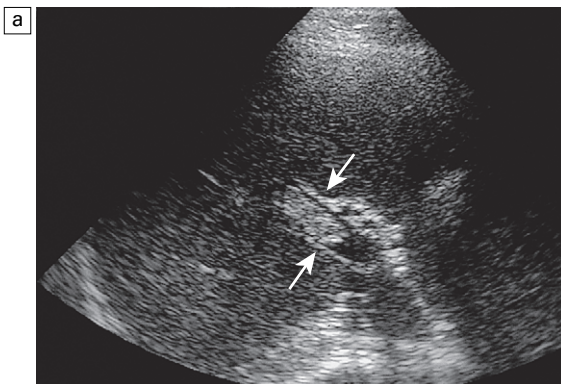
(a) Oblique image of the portal vein in a patient with hypercoagulability. Echogenic thrombus is seen adherent to the portal vein wall (arrows). (b) Colour Doppler image transverse to the portahepatis. Flow is seen coursing past the partially occluding thrombus in a hepatopetal direction.
